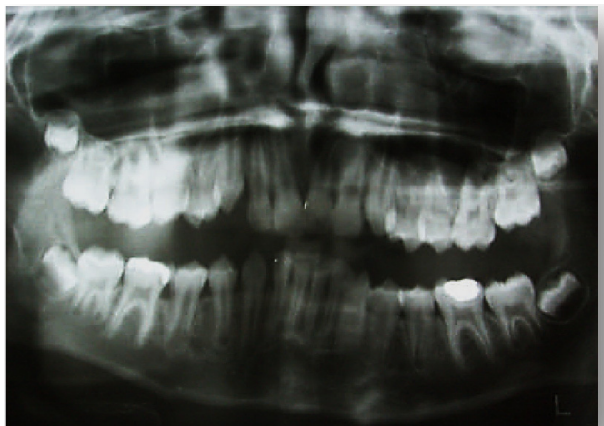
X-ray – both maxillary central incisors placed in the dental arch
